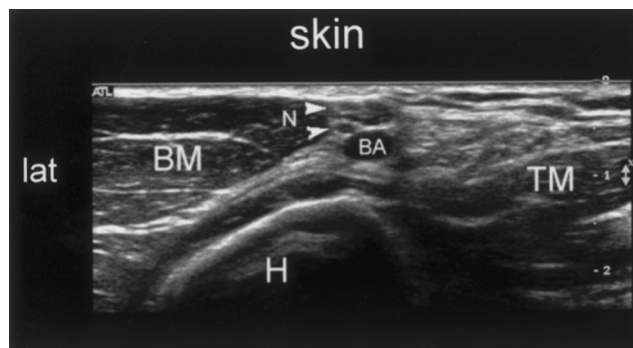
Transverse sonogram in the midhumeral region showing two terminal branches of the brachial plexus as hypoechoic nodules (*N* with arrows). BA = brachial artery; BM = biceps muscle; H = humerus; TM = triceps muscle.
